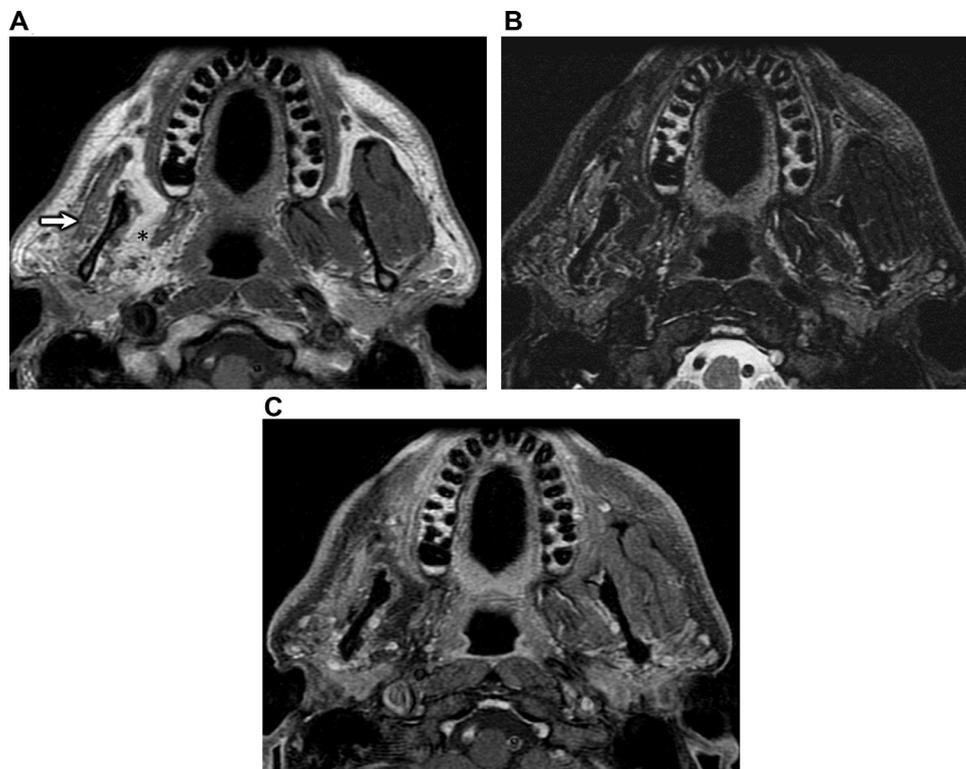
Chronic denervation injury. (A) Axial T1-weighted (B) axial T2-weighted and (C) axial T1-weighted postcontrast fat-saturated images demonstrate fatty atrophy (black asterisk) and volume loss (white arrow) of the right muscles of mastication with (B) lack of edema or (C) enhancement, indicating this is chronic in the patient previously treated with radiation for perineural tumor spread to the right V3.
